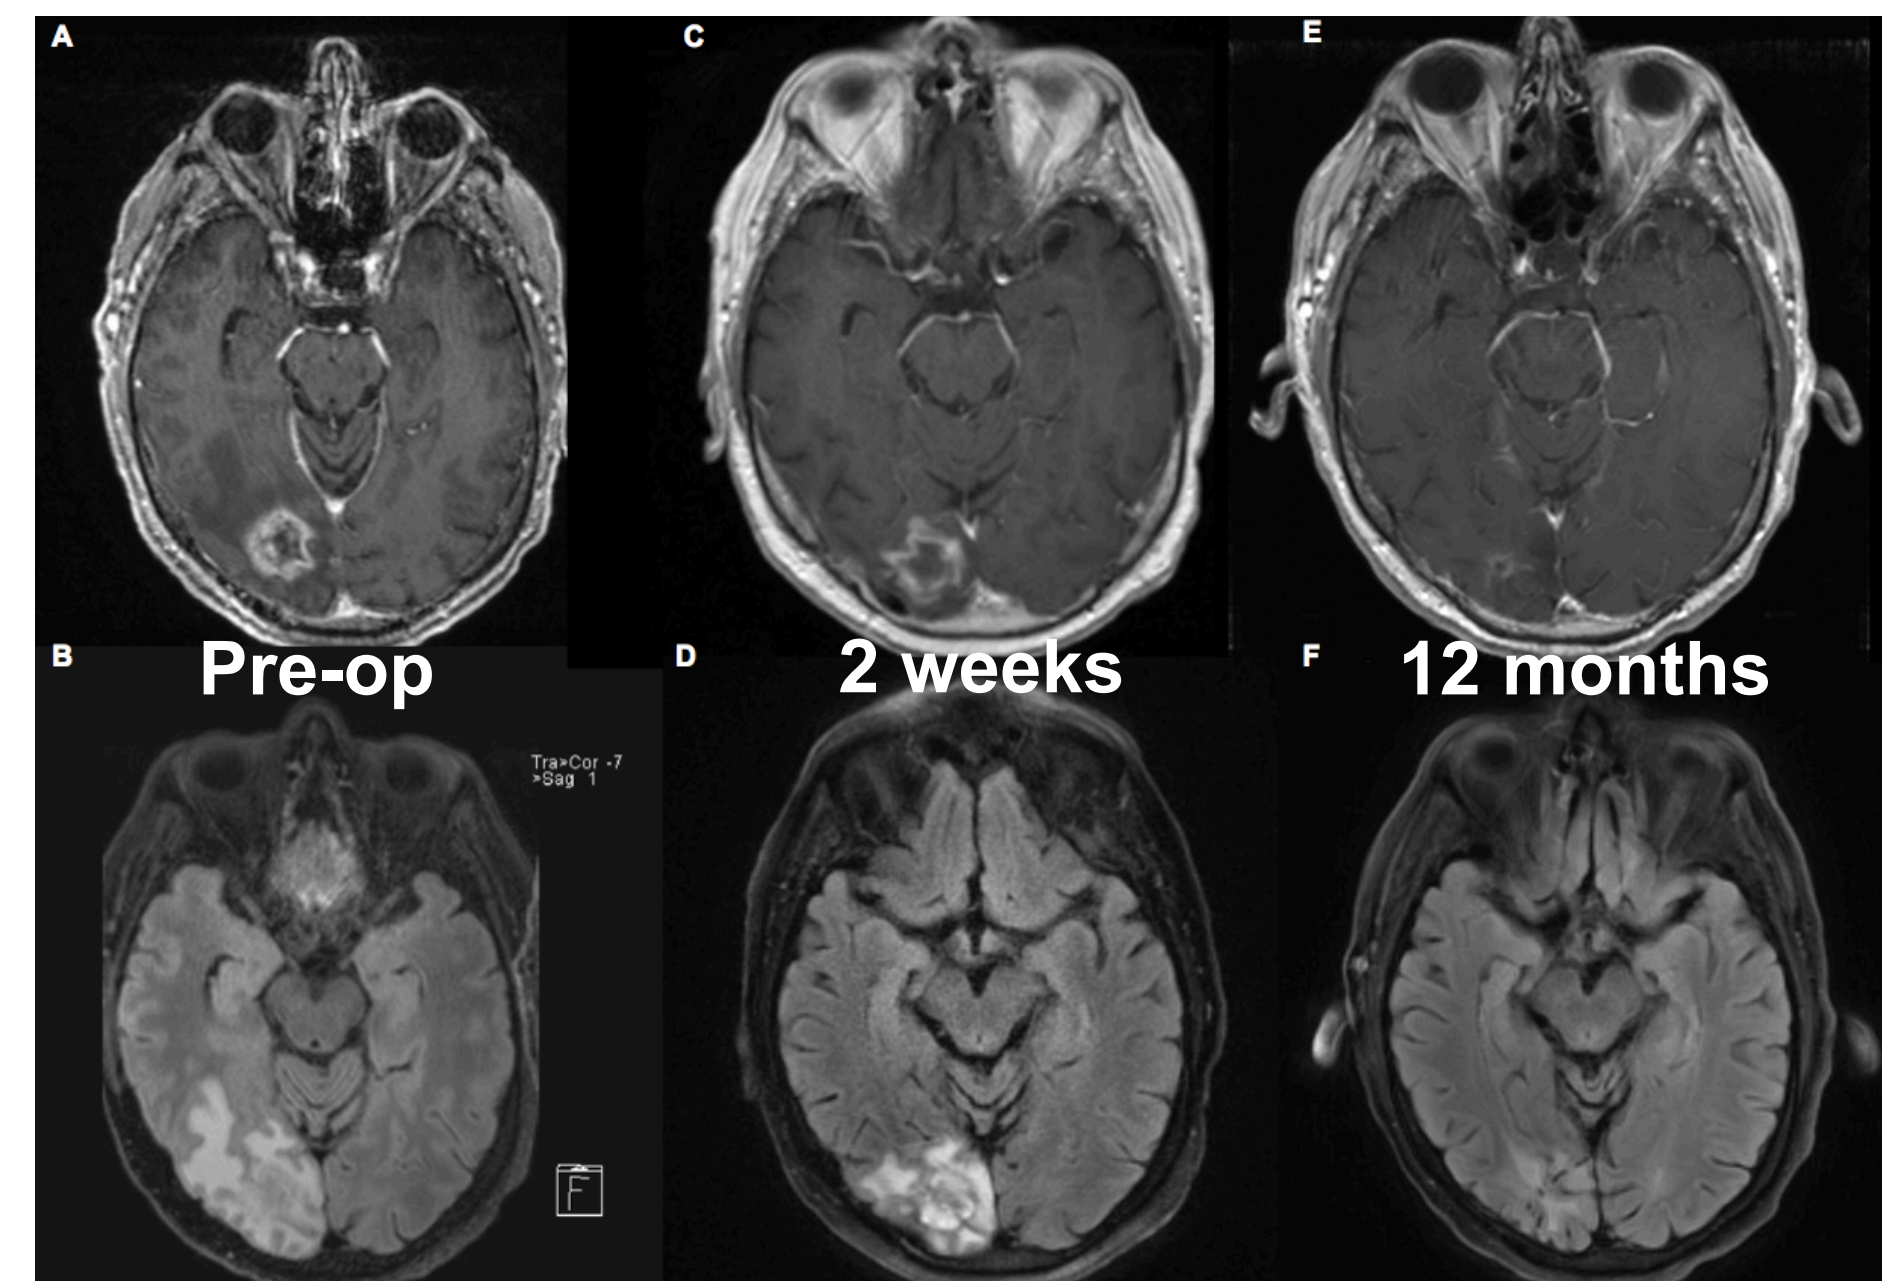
Pre-operative (A) T1 post-contrast and (B) T2 FLAIR MRI. 2 week follow-up (C) T1 post-contrast and (D) T2 FLAIR MRI. 12 month follow-up (E) T1 post-contrast and (F) T2 FLAIR MRI.
